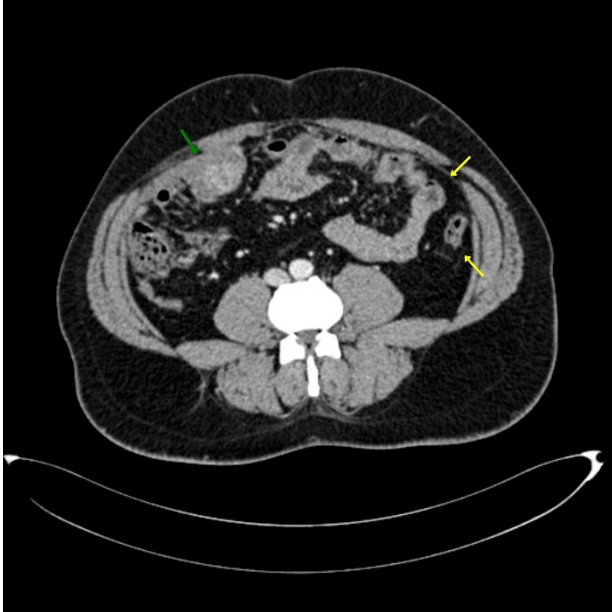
Follow-up abdominal CT with IV contrast after eight months, the right lower abdominal mass shows a marked reduction in size (green arrow), while the left lower abdominal masses have completely regressed (yellow arrows).
